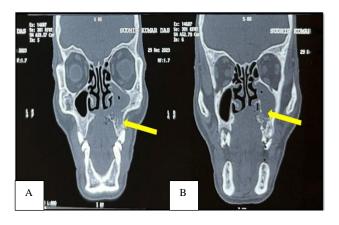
(A and B): Coronal CT scan image showing an ill-defined osteolytic lesion involving the maxilla (yellow arrows). The lesion demonstrates bone destruction and extension into the adjacent structures.
